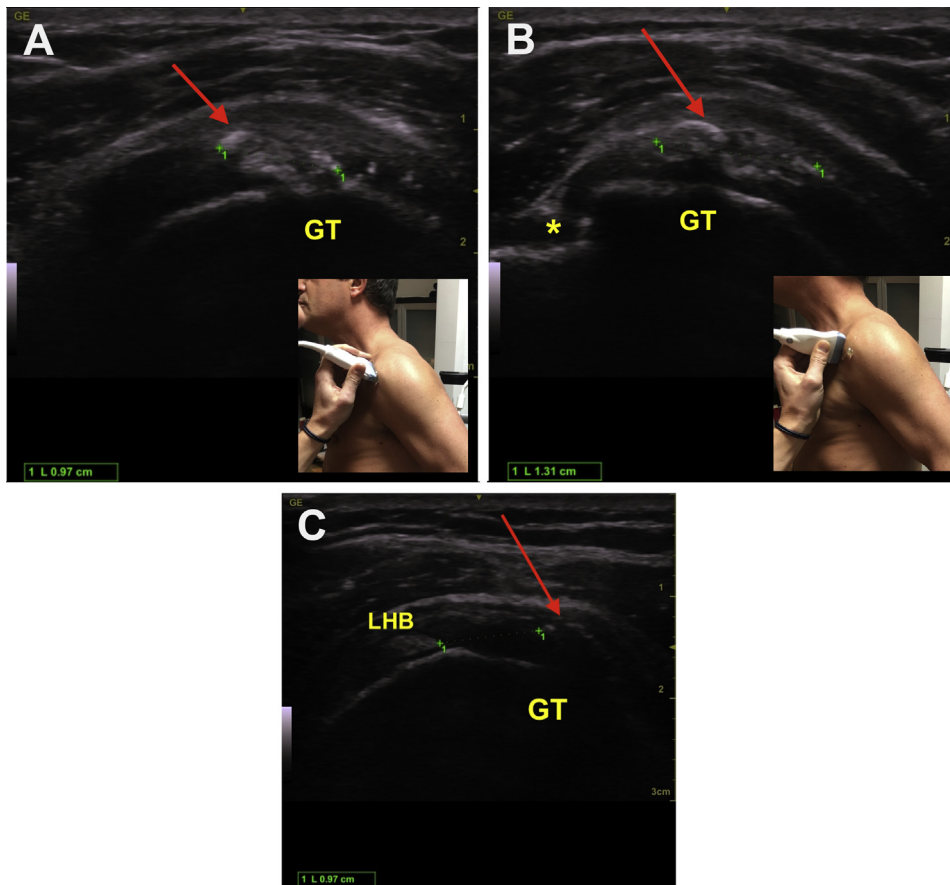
Preoperative ultrasound assessment of a calcification of the supraspinatus tendon on a left shoulder: (Arrow: calcification; *: gutter of the LHB). (A) Measurement of longitudinal section. (B) Transversal measurement. (C) Transversal measurement of the distance between the LHB at the interval of the rotator cuff and the calcification. (GT, greater tubercle; LHB, long head of the biceps.)
